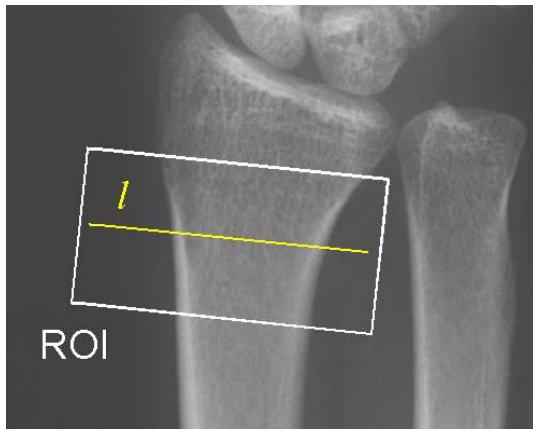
Calibrated x-ray image and a rectangular region of interest
